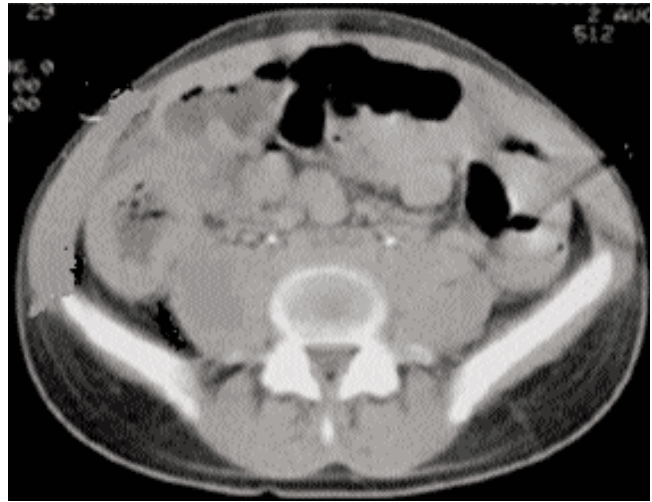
A CT scan picture of a case of Neutropenic enterocolitis showing thick walled caecum, fluid filled and dilated loops of intestines.
